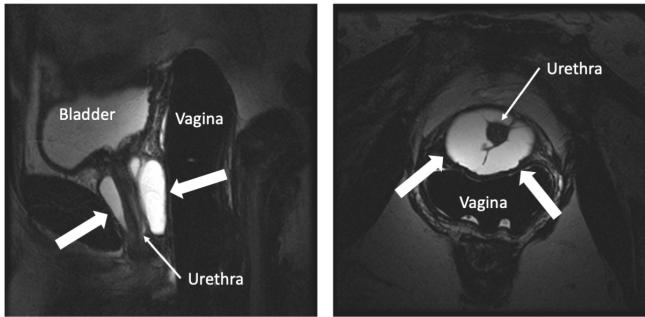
T2 weighted MRI images demonstrating sagittal (a) and axial (b) views of a circumferential urethral diverticulum. On T2 weighted images, the diverticulum will appear white (indicated by the white block arrows)
